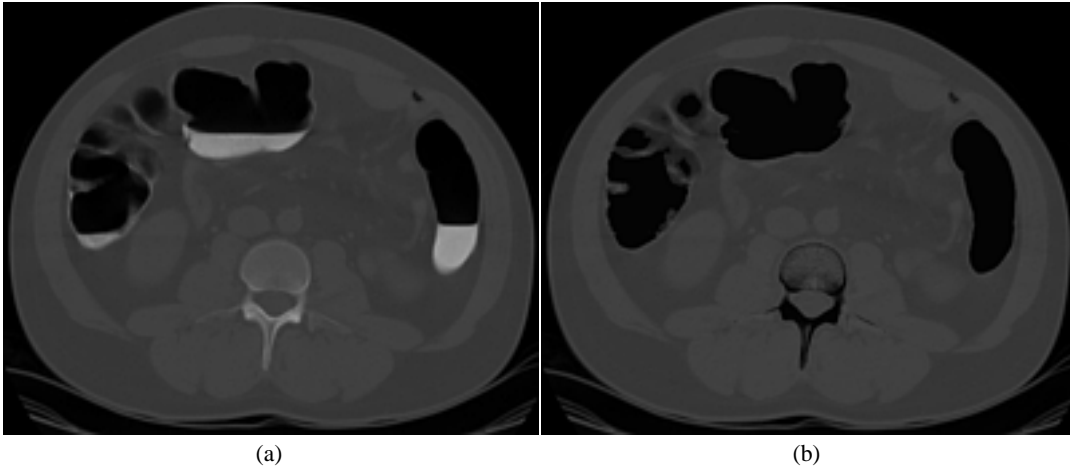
A cross-section of the CT data showing colon (a) before segmentation, and (b) after segmentation.
